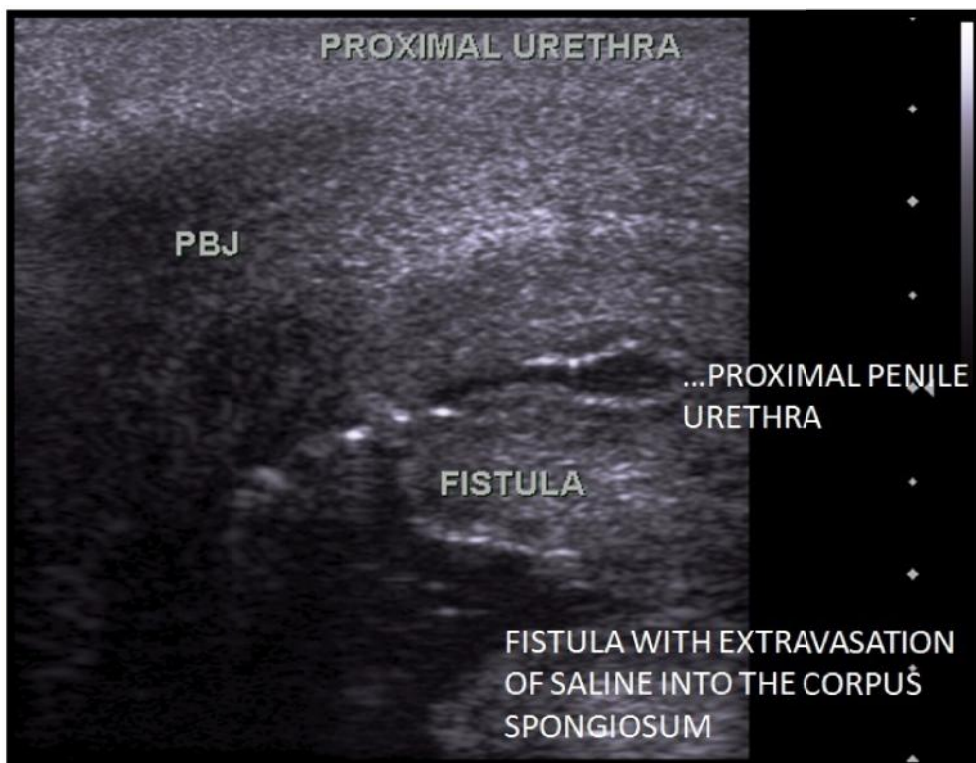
Sonographic imaging of urethral fistula.
